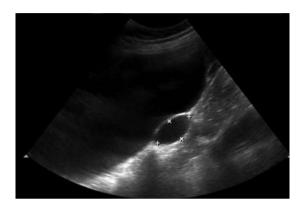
Ultrasound picture of the right ovary and right paraovarian cvst.
